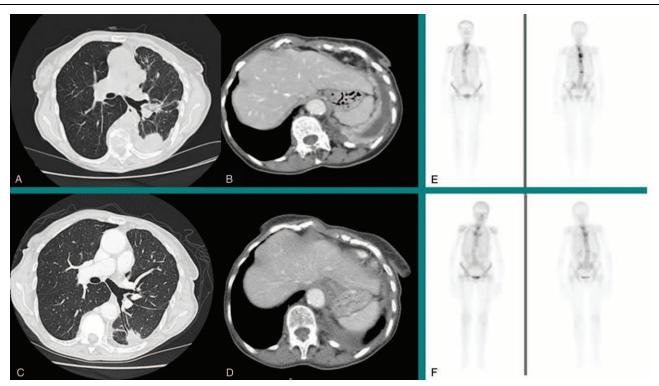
Baseline thoracic computed tomography (CT) scan demonstrating a 32 × 30 mm pulmonary mass in the posterior left inferior lobe and pleural metastases and pleural effusion in (A) and (B). The last thoracic CT scan image evaluation in (C) and (D) demonstrating stable disease with TKI gefitinib. Bone scintigraphy demonstrates metastatic bone disease in the spine and pelvis bone at baseline (E) and at the latest evaluation (F).
